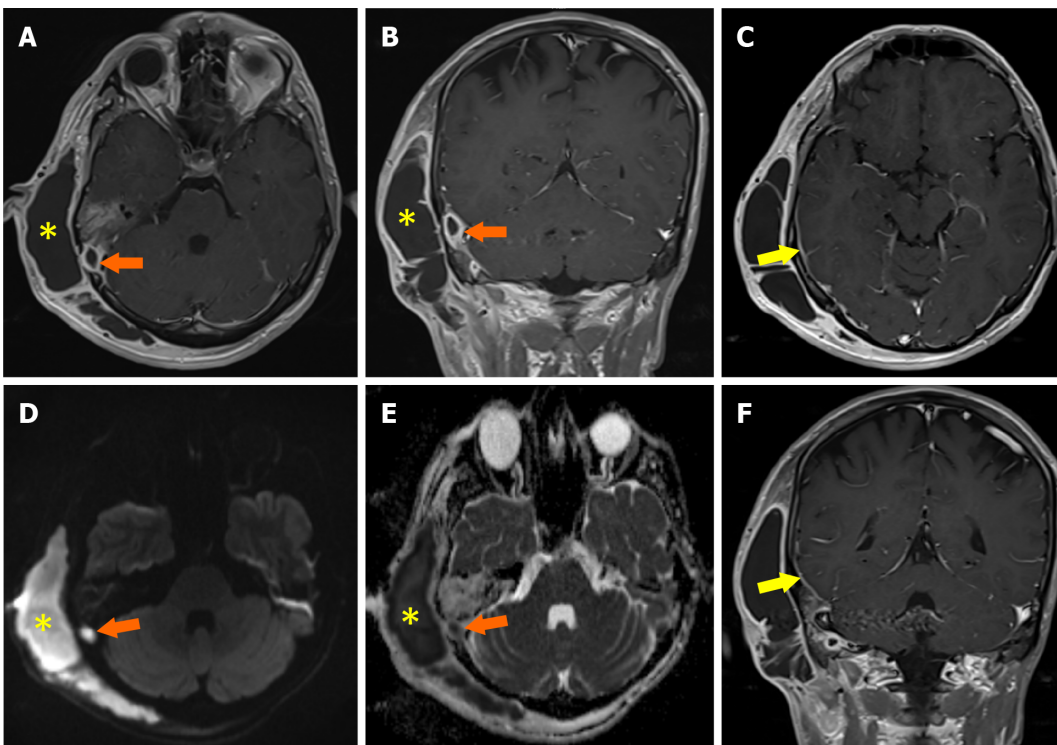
Meningitis with subcutaneous and intracranial abscess. A: The axial post-contrast T1W; B: Coronal post-contrast T1W; C: Axial post-contrast T1W; D: Axial diffusion-weighted; E: Apparent diffusion coefficient map; F: Coronal post-contrast T1W magnetic resonance images show abscesses in the subcutaneous adipose tissue (yellow asterisks) and intracranial (orange arrows) area with a thick and hyperenhanced wall and centrally restricted diffusion. The axial post-contrast T1W and coronal post-contrast T1W magnetic resonance images show meningeal enhancement compatible with meningitis in the right parietotemporal area (yellow arrows).
